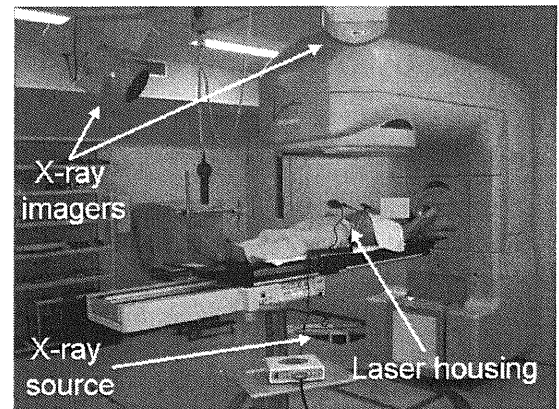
The experimental setup is shown. The patient's abdomen is monitored by the RespGate system, a laser displacement device attached to the couch. The position of the internal gold bb is monitored by the stereoscopic fluoroscopy (only one x-ray source is visible in the picture). Note that for certain gantry angles, one of the x-ray imagers may be obscured.
